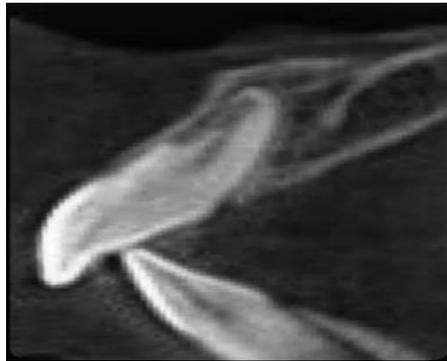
CBCT scan of tooth #2.1.
